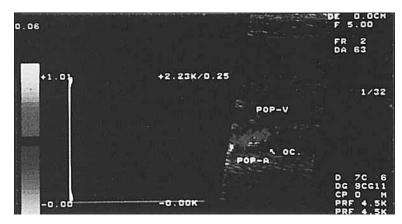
Absence of color-flow and image-directed Doppler signals in the left popliteal artery.
